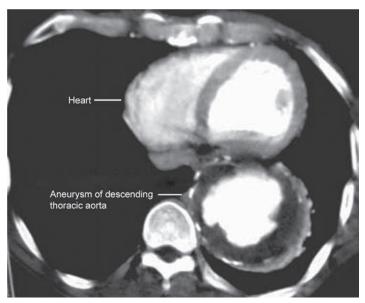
In another case contrast CT shows that the lumen of aneurysmal segment is entirely filled with contrast except at periphery, which has hypodense nonenhancing thrombus *in situ*
